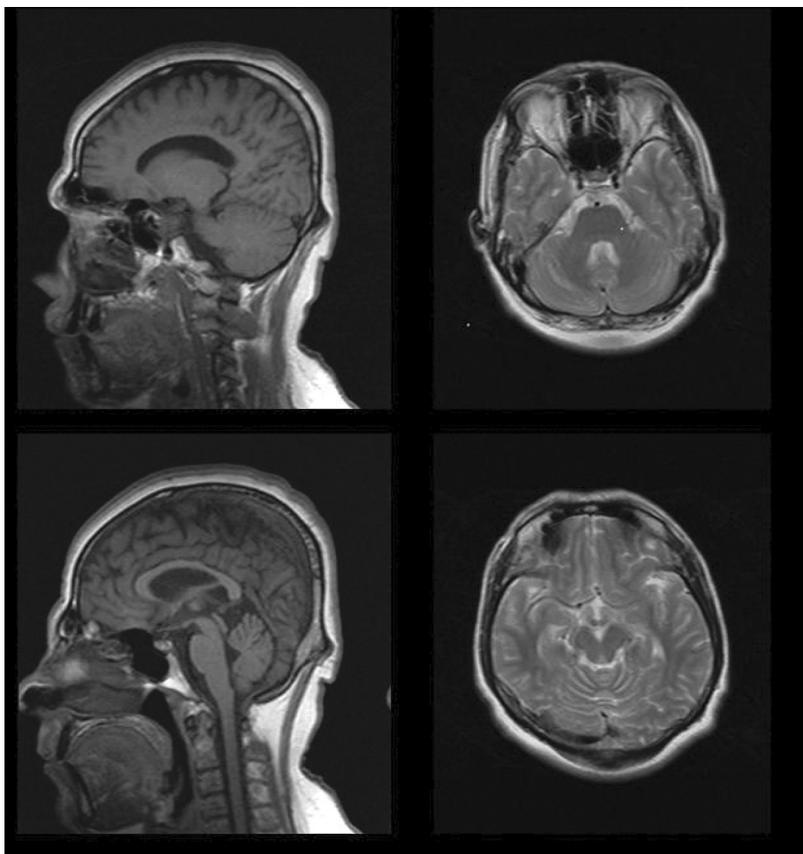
MRI scans for the quadruped man. Left: sagittal sections, above normal cerebellum, below mild vermian atrophy; Right: coronal section, above normal cerebellum, below mild atrophy in cerebellar vermis.
